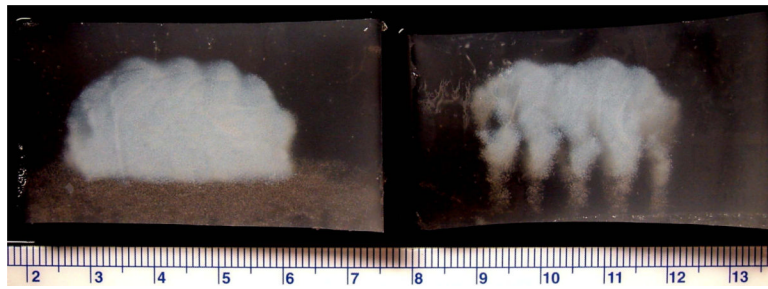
Macroscopic (top) and T2-weighted MR (bottom) images of spiral compound lesions, performed with ADV and acoustic trench (left) and without either (right).
